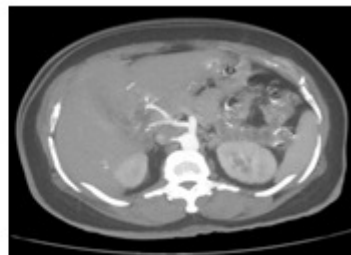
Contrast enhanced CT of the abdomen arterial phase axial section Maximum intensity projection (MIP) images showing origin of common hepatic artery from superior mesenteric artery
